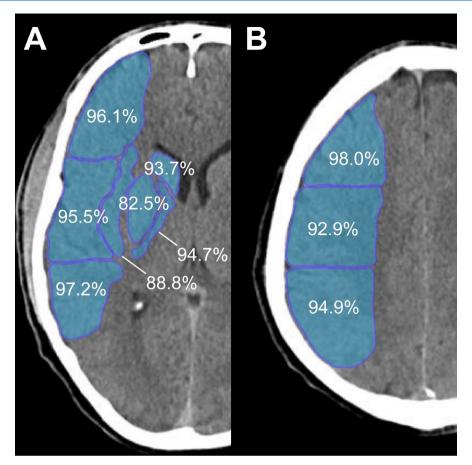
e-ASPECTS accuracy by region at the level of the basal ganglia (A) and the supraganglionic level (B).
